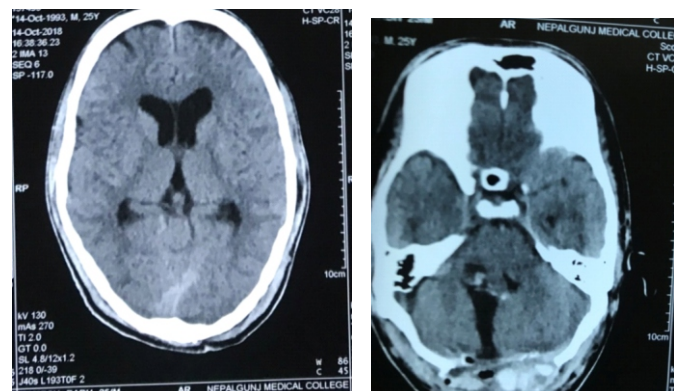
Post operative CT scan pictures
